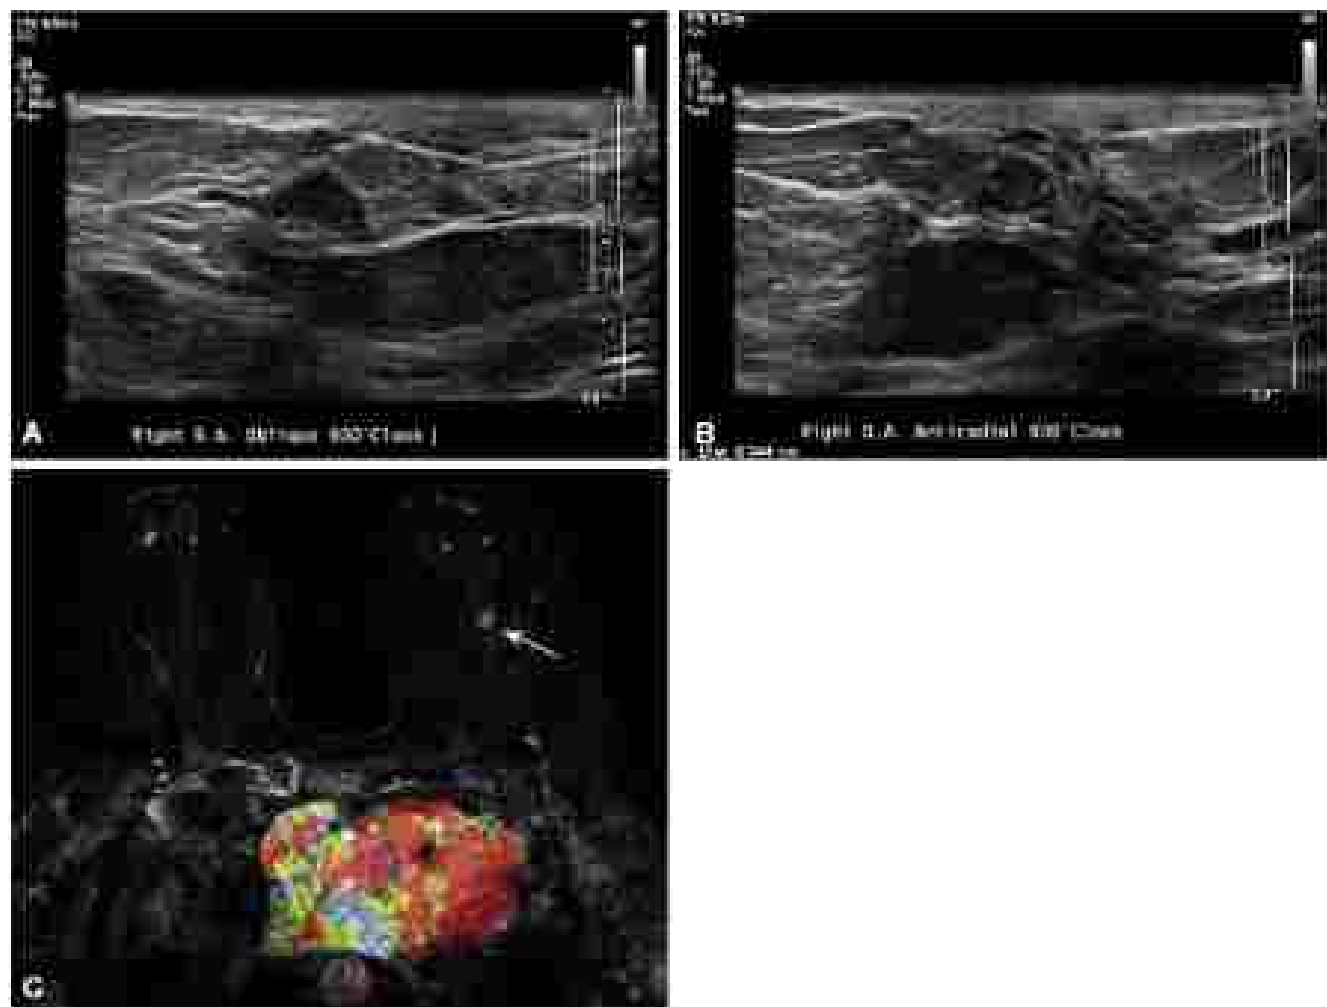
Coronal (A) and axial (B) mammographic images of a subcutaneous intraductal mass in a 54-year-old woman who presented with unilateral, bloody, spontaneous nipple discharge, later biopsy-proven to be an intraductal papilloma. (C) Contrast-enhanced magnetic resonance image with color kinetic overlay performed on a 51-year-old woman with spontaneous and clear nipple discharge in the left breast, which demonstrated a subcutaneous heterogeneously enhancing mass in the central left breast, also later biopsy-proven to be a papilloma.
